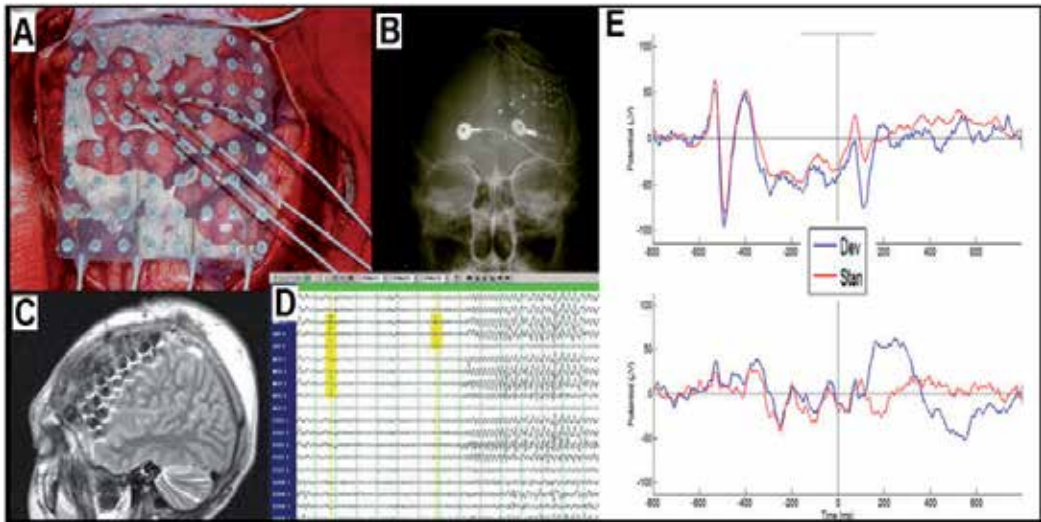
Intracranial recordings. A) Grid of 63 electrodes for electrocorticography in a patient with refractory epilepsy. B) X-ray computed tomography (CT) and C) MRI showing the electrode grid and deep electrodes for local field potentials. D) Intracranial EEG. E) iERP recordings of deviant (DEV, Blue) and standard (STA, Red) stimuli during a global-local oddball task. Selected electrodes demonstrated an N2 and P3 modulation at the frontal (above) and parieto-temporal sites (below).
